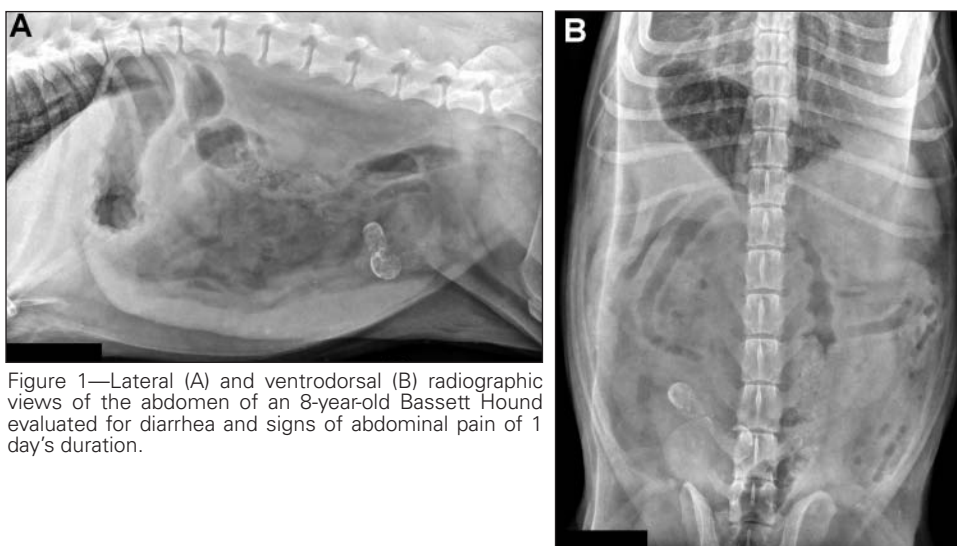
Lateral (A) and ventrodorsal (B) radiographic views of the abdomen of an 8-year-old Bassett Hound evaluated for diarrhea and signs of abdominal pain of 1 day's duration.
